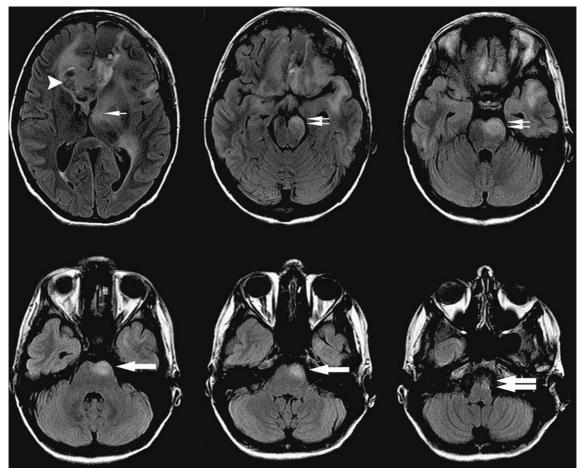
Consecutive postoperative axial fluid-attenuated inversion recovery magnetic resonance images demonstrate the tumor (arrowheads). A hyperintense signal follows the left corticospinal tract from the internal capsule (single thin arrow), the cerebral peduncle (pair of thin arrows), the pons (single thick arrow) to the medulla oblongata (pair of thick arrows).
